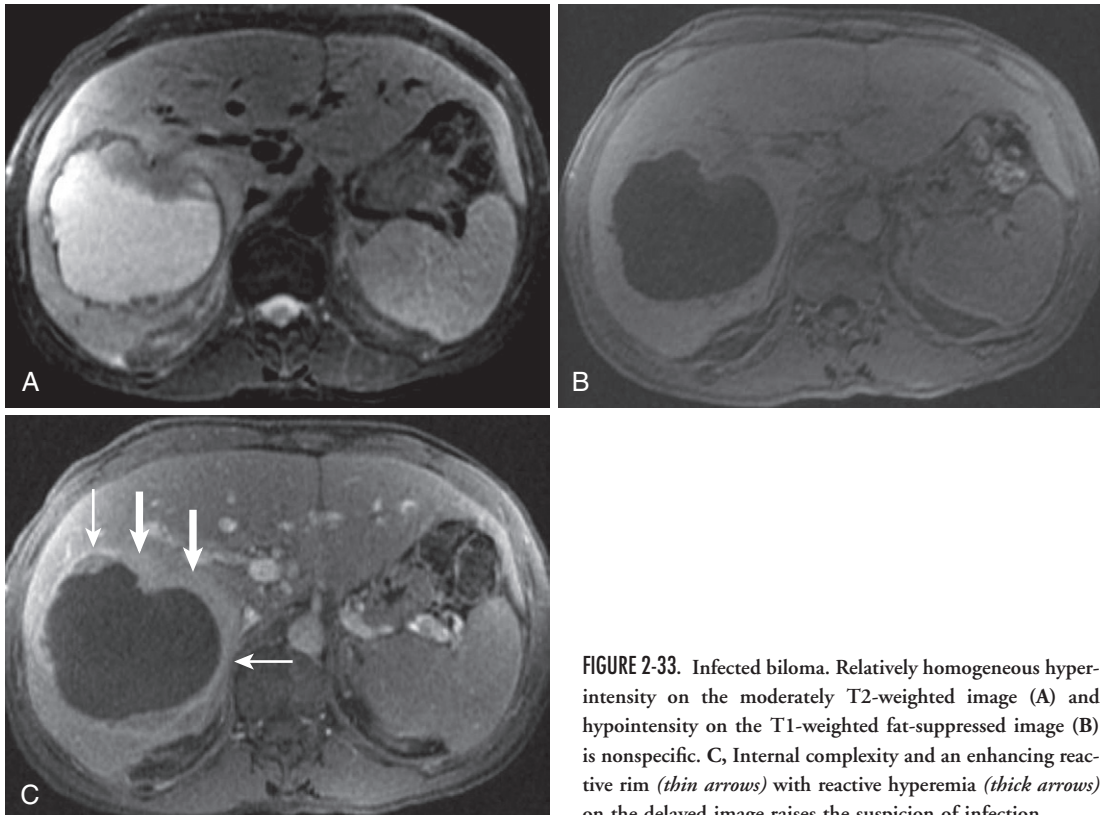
Infected biloma. Relatively homogeneous hyperintensity on the moderately T2-weighted image (A) and hypointensity on the T1-weighted fat-suppressed image (B) is nonspecific. C, Internal complexity and an enhancing reactive rim (*thin arrows*) with reactive hyperemia (*thick arrows*) on the delayed image raises the suspicion of infection.
